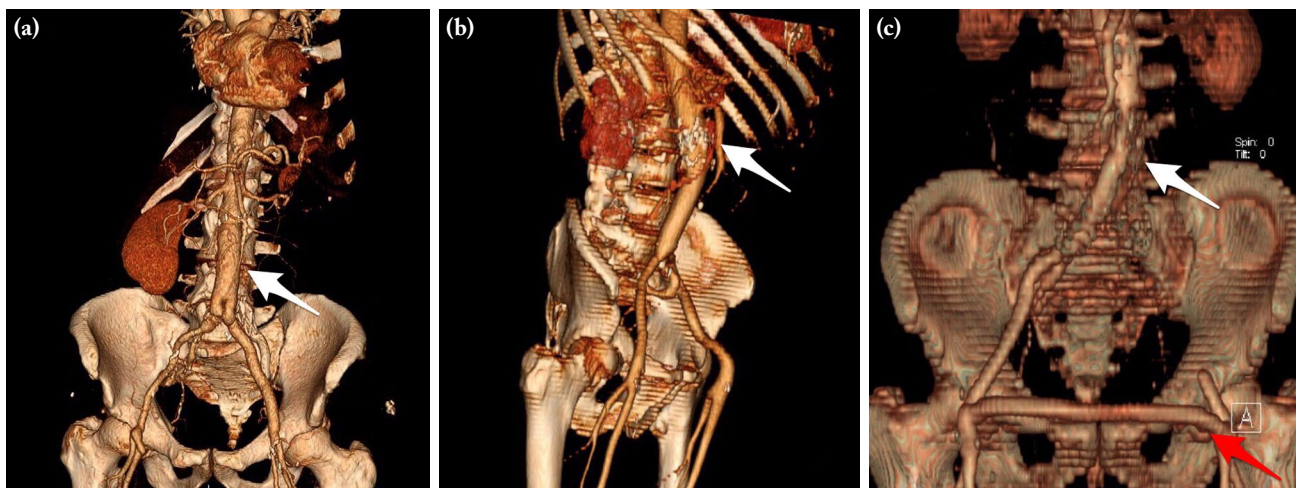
Three-dimensional computed tomographic angiography showed different techniques in surgical conversion after EVAR; (a) aortobiiliac bypass graft after total endograft explantation; (b) bilateral aortofemoral bypass after partial endograft explantation; (c) cross-femoral bypass (red arrow) with total endograft preservation in a patient with left iliac limb occlusion of endograft (white arrow).
